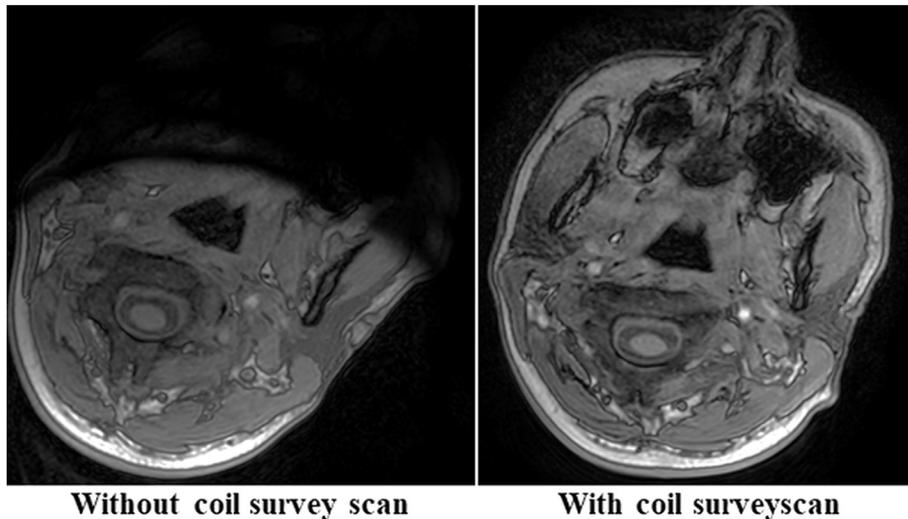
Signal loss or FOV cutoff due to the rotation of the receive coil (left image) and the FOV was recovered (right image) by performing a coil survey scan after every rotation in the second volunteer MRI.
